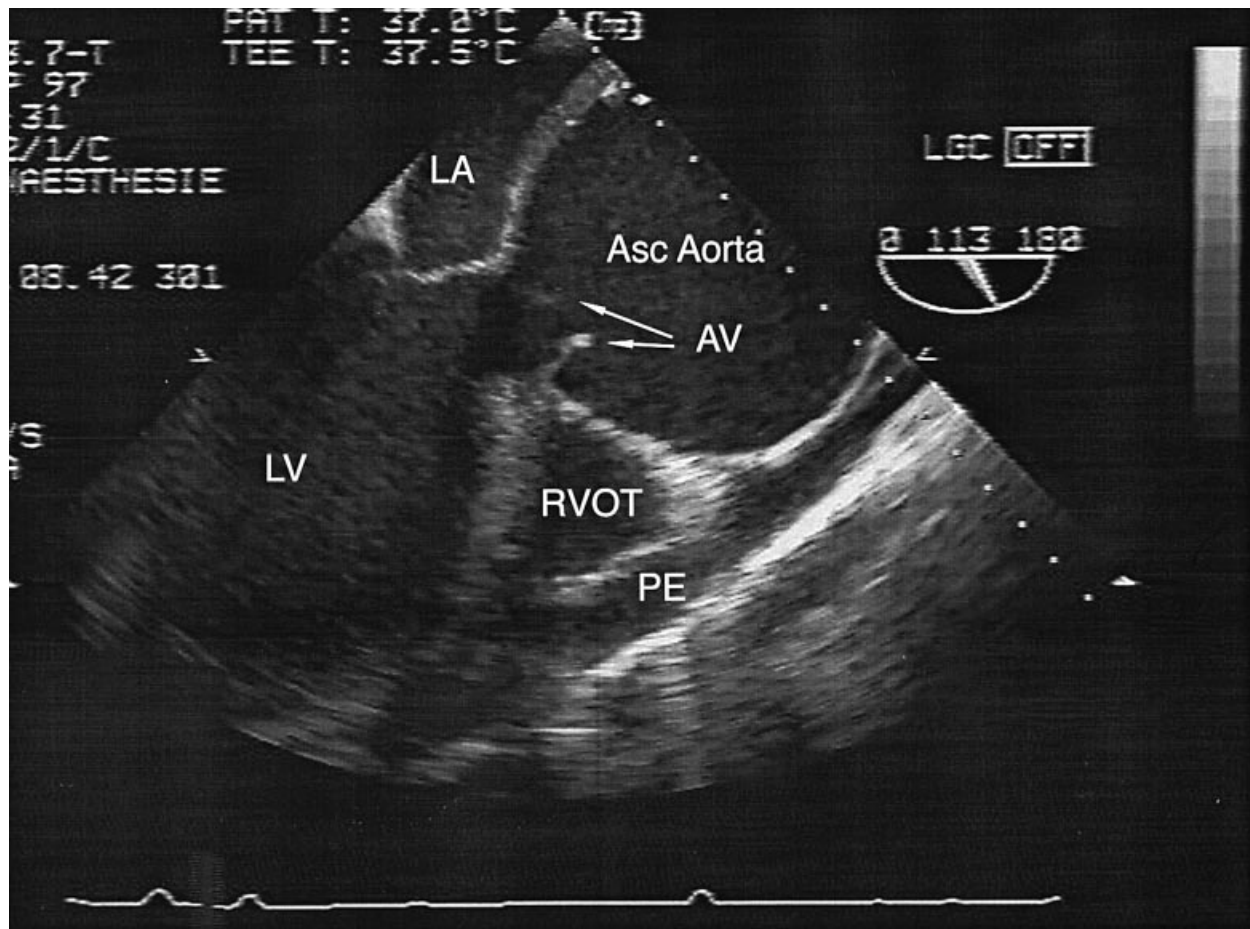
Transoesophageal oblique view of the left ventricular outflow tract. Abbreviations: LA=left atrium; LV=left ventricle; AV=aortic valve; Asc Aorta=ascending aorta; RVOT=right ventricular outflow tract; and PE=pericardial effusion.
